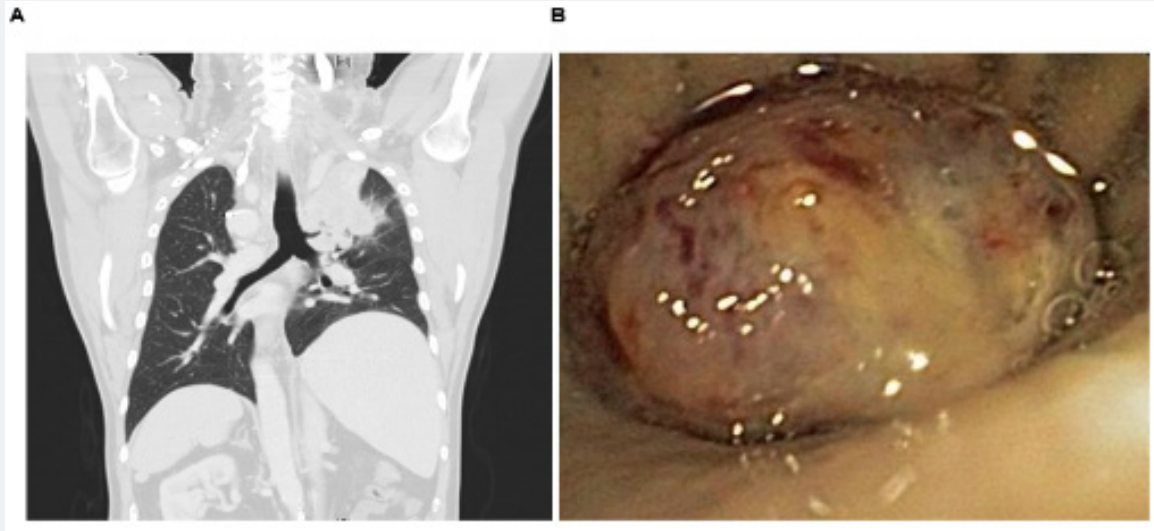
and 1B: A) Computed tomography scan showing situs inversus, left tracheal bronchus and lung cancer. B) Left tracheal bronchus with endobronchial mass.
